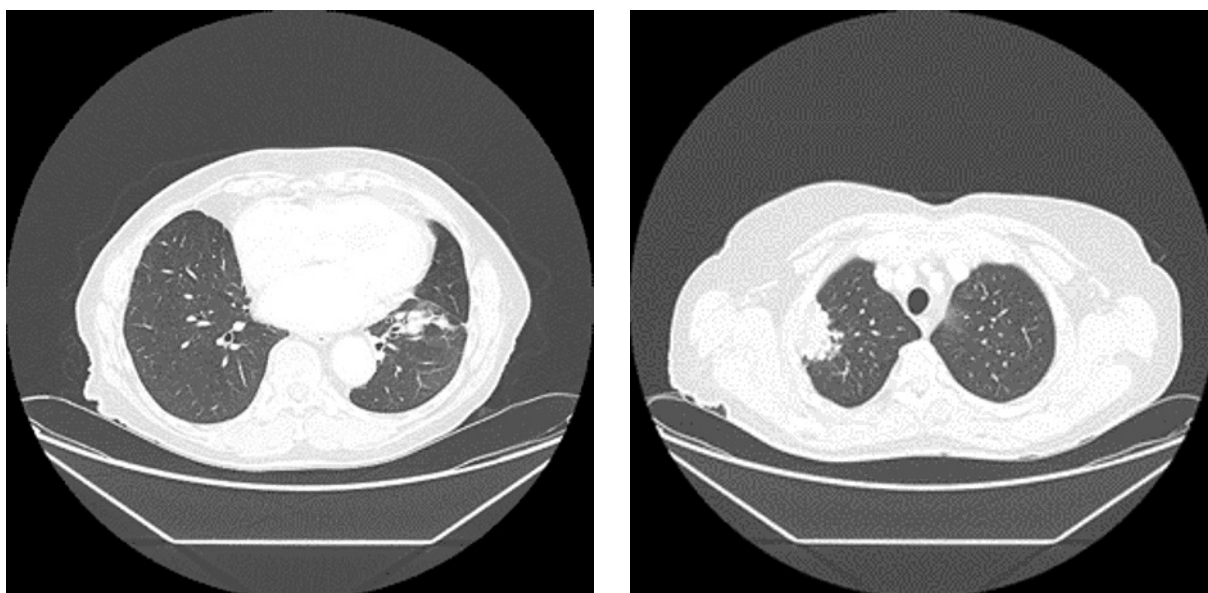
Lung metastases CT scan images of patient treated with vismodegib due to BCC, 31.10.2017 (description in the text)
